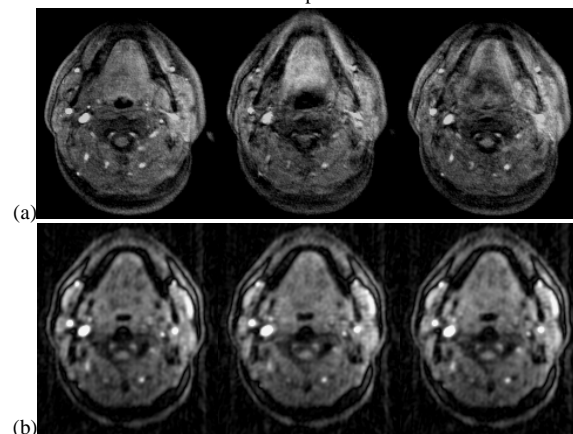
TurboFLASH images (a) and projection reconstruction-MRI images (b) with no motion (left), cough (middle), and swallow (right).
